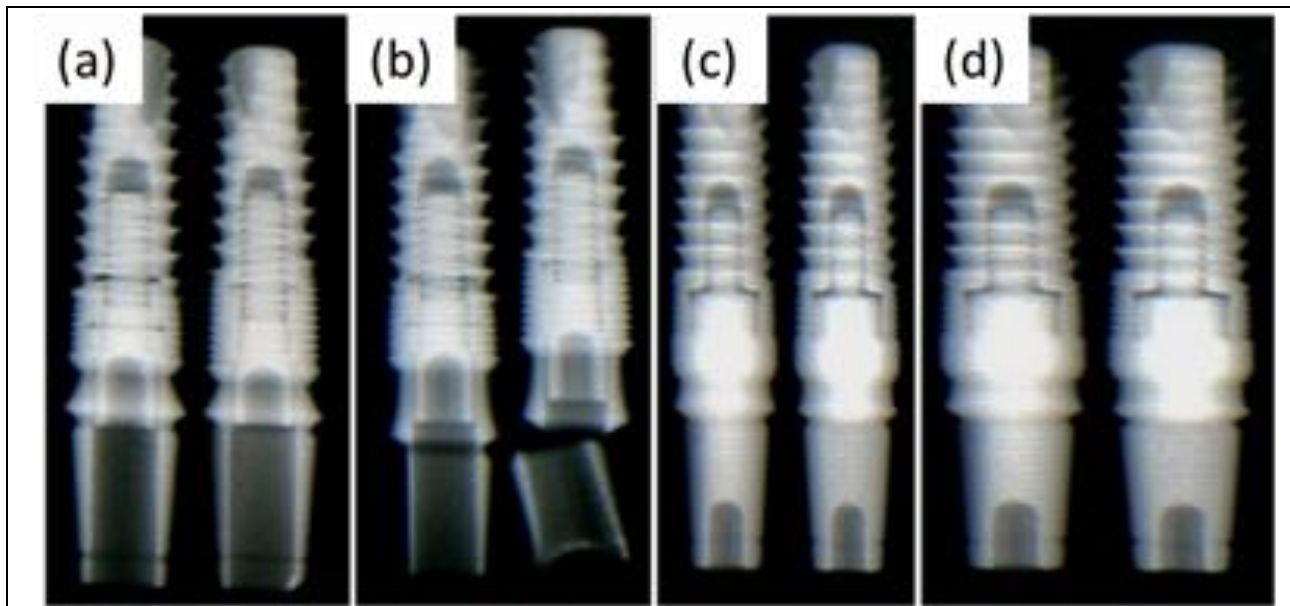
Implant system radiograph images
